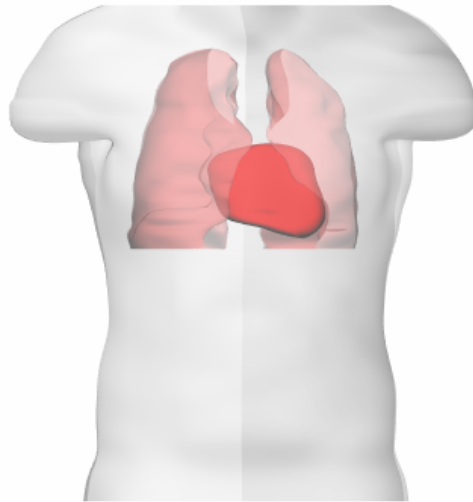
The MRI-derived surface lung mesh in relation to the torso and heart models from the University of Auckland.*
